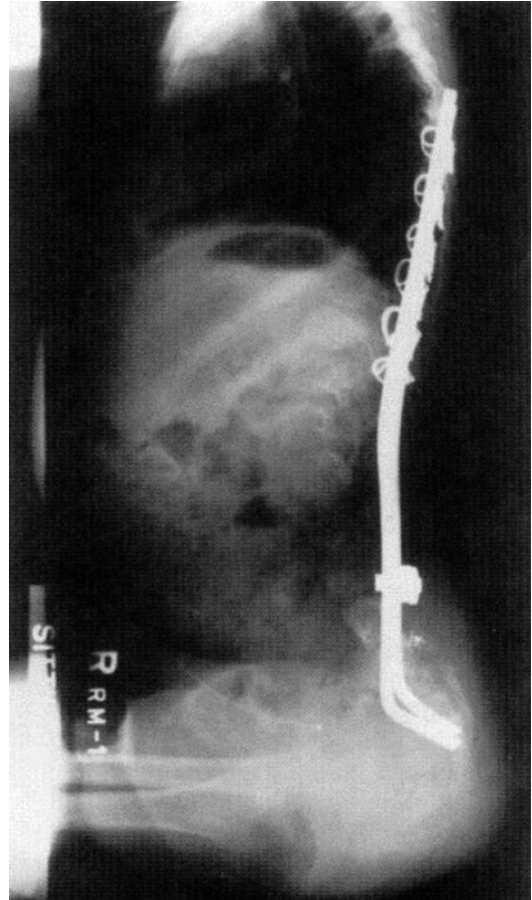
6-month postoperative x-ray of same patient with demonstration of kyphotic reduction with Luque rods (Reprinted from McCall [22] with permission from Wolters Kluwer Health)
